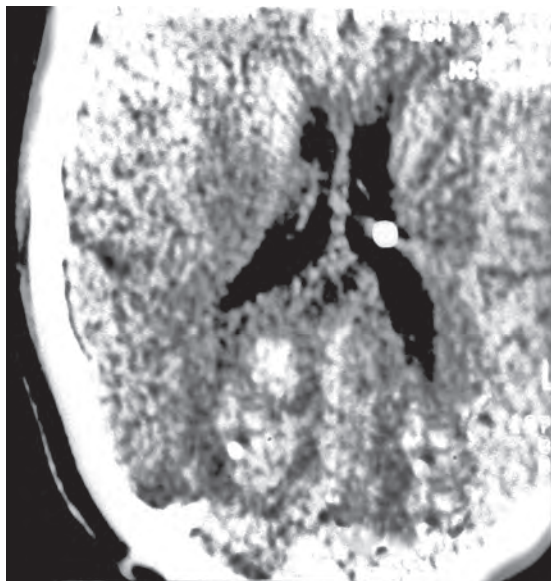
CT brain showing retained intraventricular splinters
